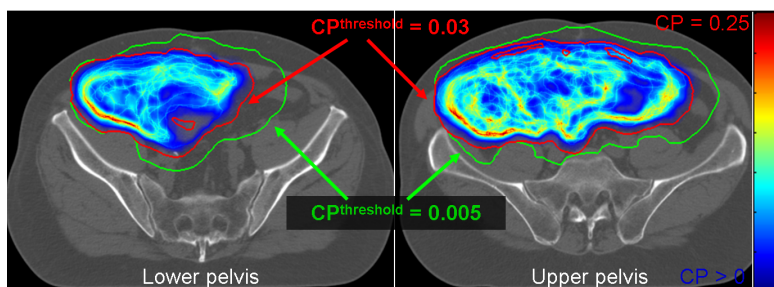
Example of PRVs created from 3 CT scans and overlaid on the CP matrix created from all 11 available CTs. A generous PRV (green) was obtained by applying a CP threshold of 0.005, while a tighter PRV (red) was obtained by applying a CP threshold of 0.03.
